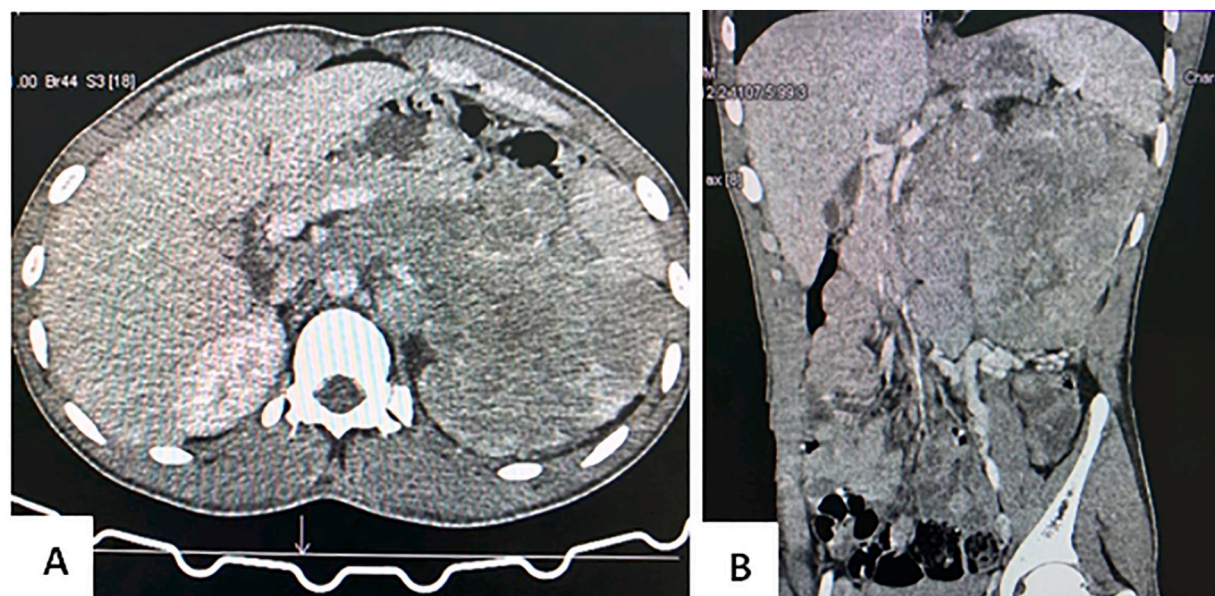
Axial contrast enhanced CT of abdomen demonstrating large heterogeneously enhancing mass lesion replacing the left renal parenchyma with renal vein infiltration (A). Coronal reformatted image showing left renal mass with multiple conglomerate periaortic nodes (B).
